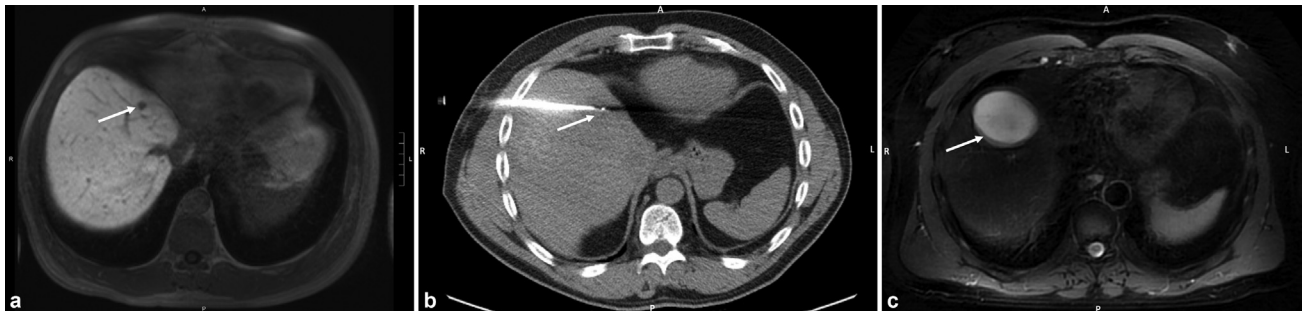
(a) Axial T1-weighted image of the liver demonstrating a colorectal metastasis (white arrow). (b) Axial CT scan demonstrating MWA of the colorectal metastasis. (c) Axial T2-weighted image 6 months post-MWA which demonstrates a biloma (white arrow). Patient was asymptomatic.
